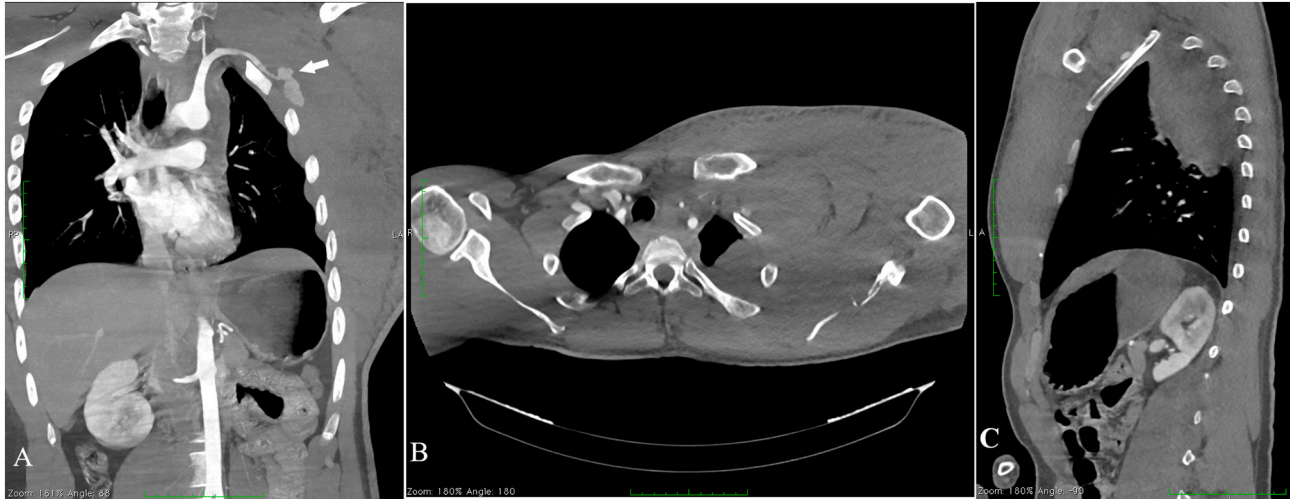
Preoperative computed tomography scan. (A) The coronal plane where the white arrow indicates the area of extravasation following the complete transection of the left subclavian artery. (B) Axial plane showing the haematoma of the left hemithorax and the comminuted fracture of the left scapular body. (C) Sagittal plane showing the haematoma at the apex of the left lung.
